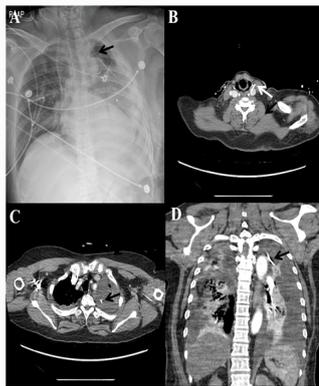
Internal jugular vein catheter malposition. Chest X-ray (A) shows the tip of the line at the left lung (arrow) with a large amount of left pleural effusion. Contrast chest computed tomography scan demonstrated the tip of the left internal jugular catheter placed in the left pleural cavity (B and C, arrows) with bilateral pleural effusion (B–D).
